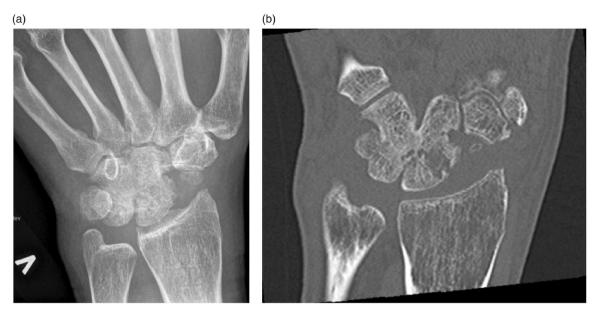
(a) Frontal radiographs, 1 year follow-up, 4CF considered healed. (b) Frontal CT projection demonstrating non-union around the lunate. Later conversion to arthroplasty confirmed non-union.
